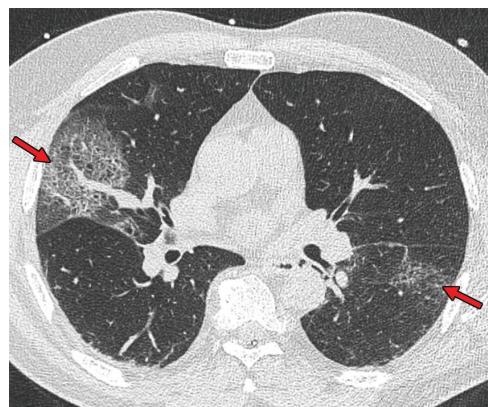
Crazy-paving pattern in a 66-year-old man with COVID-19. Axial nonenhanced chest CT image shows ground-glass opacities, with superimposed septal thickening (arrows) in the middle lobe and left lower lobe.
